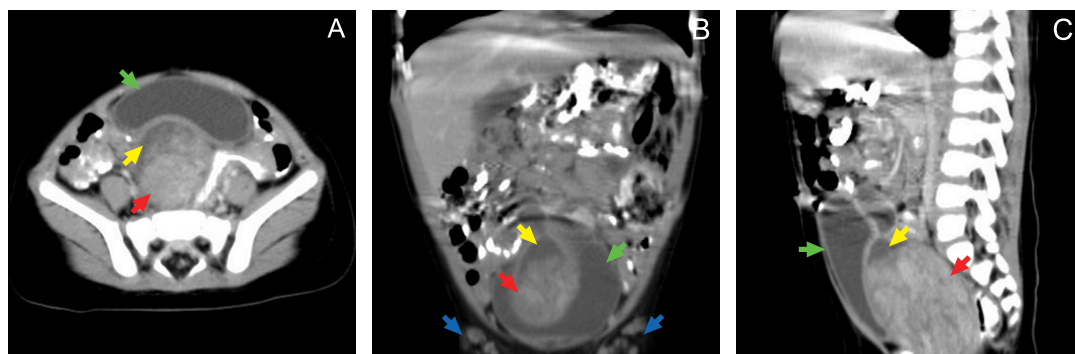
Abdominal computed tomography taken on admission, showing a large, fairly defined, heterogeneously enhancing soft tissue, measuring 6.4 x 5 x 4.3 cm, noted at the region of the cervix and uterus (A, B, and C: red arrows). Cystic components are seen contiguous to the enhancing mass (A, B, and C: yellow arrows). The sigmoid colon is compressed, demonstrating wall thickening. The mass causes compression and displacement of the urinary bladder anteriorly (A, B, and C: green arrows). Multiple enhancing lymph nodes are seen in the left and right inguinal areas (B: blue arrows).
